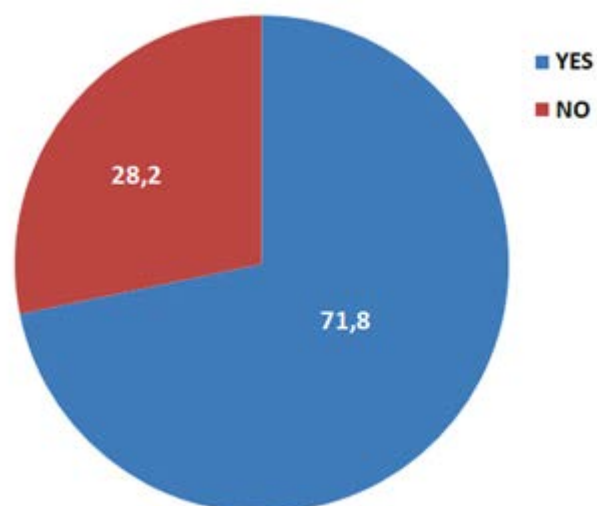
STUDY/PROFESSIONAL EXPERIENCE TO RECEIVE FEEDBACK ON ABILITY TO DEEPLY RESPECT OTHERS
